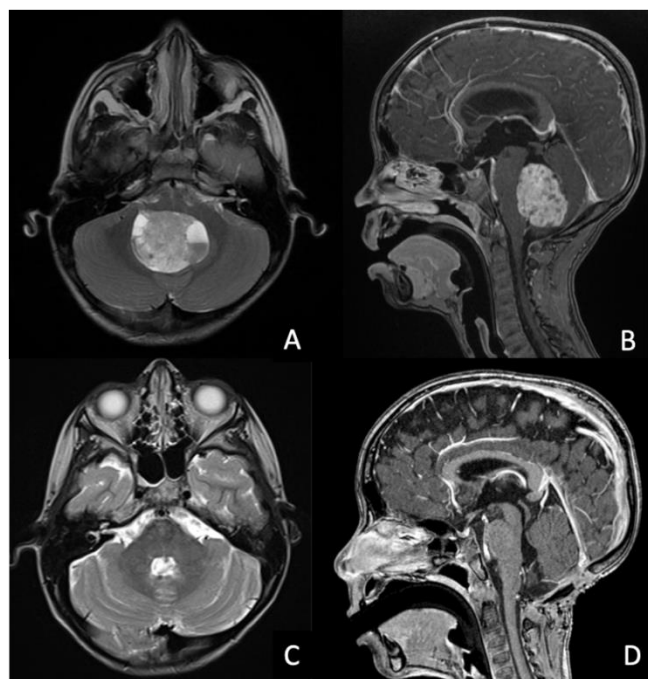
Preoperative MRI showing a heterogenic fourth ventricle mass in Axial T2-weighted (A) and sagittal contrast enhanced images(B), and postoperative exam showing gross total resection of the medulloblastoma Axial T2-weighted (C) and sagittal contrast enhanced images (D).
